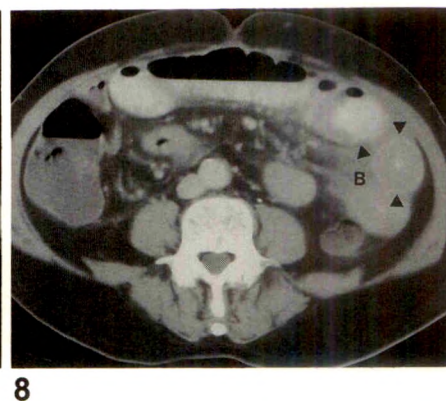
Intramural hemorrhage associated with anticoagulant therapy. CT scan of jejunal segment in left upper abdomen shows concentric wall thickening (arrowheads) and high-density fluid (blood, B) in adjacent mesentery.
